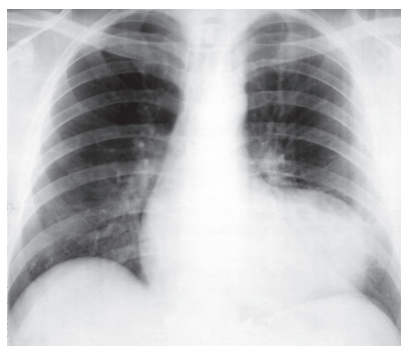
Frontal X-ray. Local expansion of the heart silhouette due to aneurysm of the left ventricle of the heart
